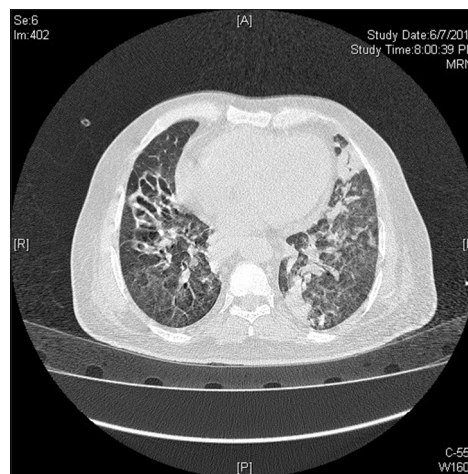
High-resolution computed tomography chest shows bilateral diffuse ground glass appearance, areas of consolidation, discrete nodules, and bronchiectatic changes
